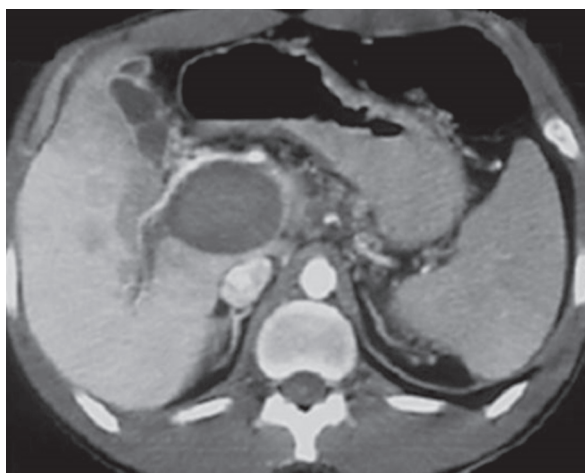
Thrombosed portal vein aneurysm. Contrast-enhanced CT scan at the level of the hepatic hilum shows an aneurysm of the main portal vein with complete thrombosis.
